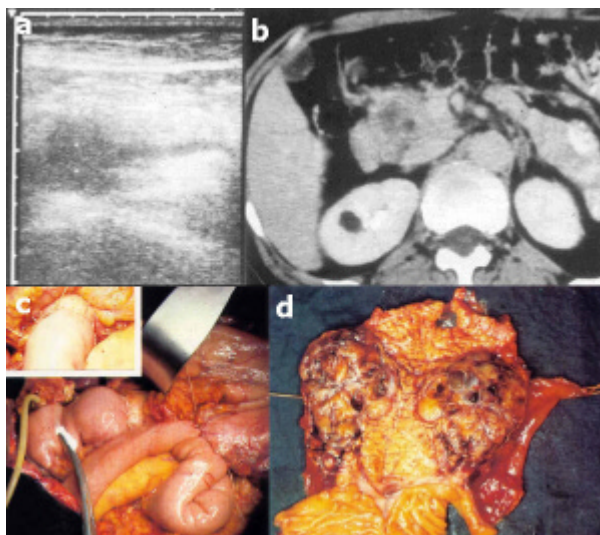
Case 2. US showing a solid mass of the pancreatic head, 4 cm in diameter, not well-defined and without an evident capsule, mimicking a ductal adenocarcinoma (a.). A contrast-enhanced CT scan confirmed the ultrasound findings and revealed, with a non-homogeneous mass of uneven soft-tissue density with central necrosis (b.). A pylorus-preserving pancreaticoduodenectomy was performed (c.) and the mass appeared as a solid and cystic lesion (d.). (Image d. is presented in another contribution by the same authors, published in these Proceedings [30], in order to describe aspects not related to those reported here)
